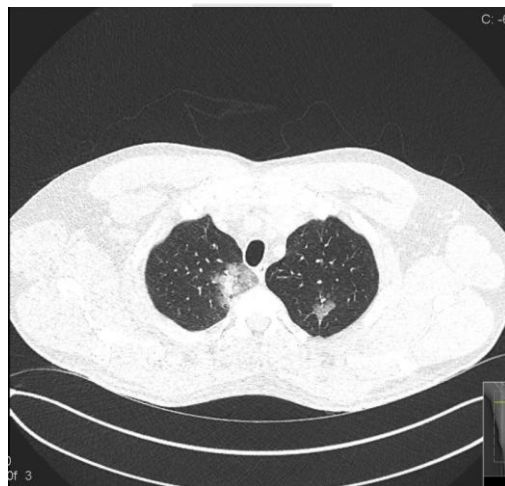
HRCT performed on first admission showing focal area of ground glass opacities noted in apical segments of both lungs. There was also a couple of small volume pre-tracheal lymph nodes present, with no evidence of mass lesions or nodules. The rest of the lung parenchymal attenuation is normal.
